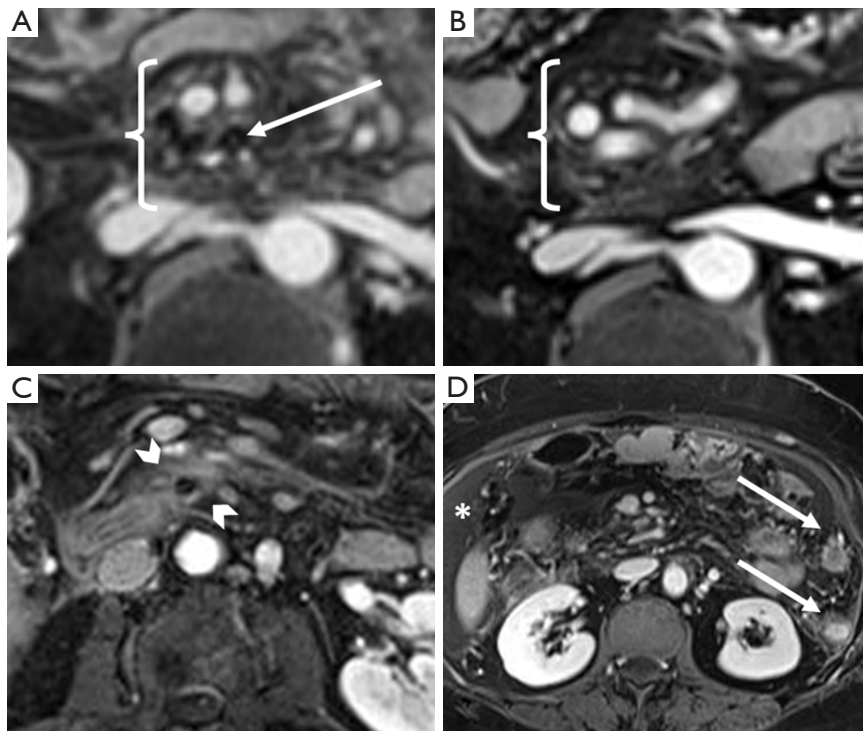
Surveillance imaging. Axial venous MR images at (A) 2 months and (B) 18 months postoperation reveal hazy stranding around the mesenteric vessels (bracket), which continues to improve with time (black signal voids represent surgical clips, arrow). In another patient, axial venous MR postoperative images revealed (C) solid soft tissue recurrence surrounding a surgical clip (chevrons), (D) in addition to peritoneal nodules (arrows) and ascites (asterisk). MR, magnetic resonance.
